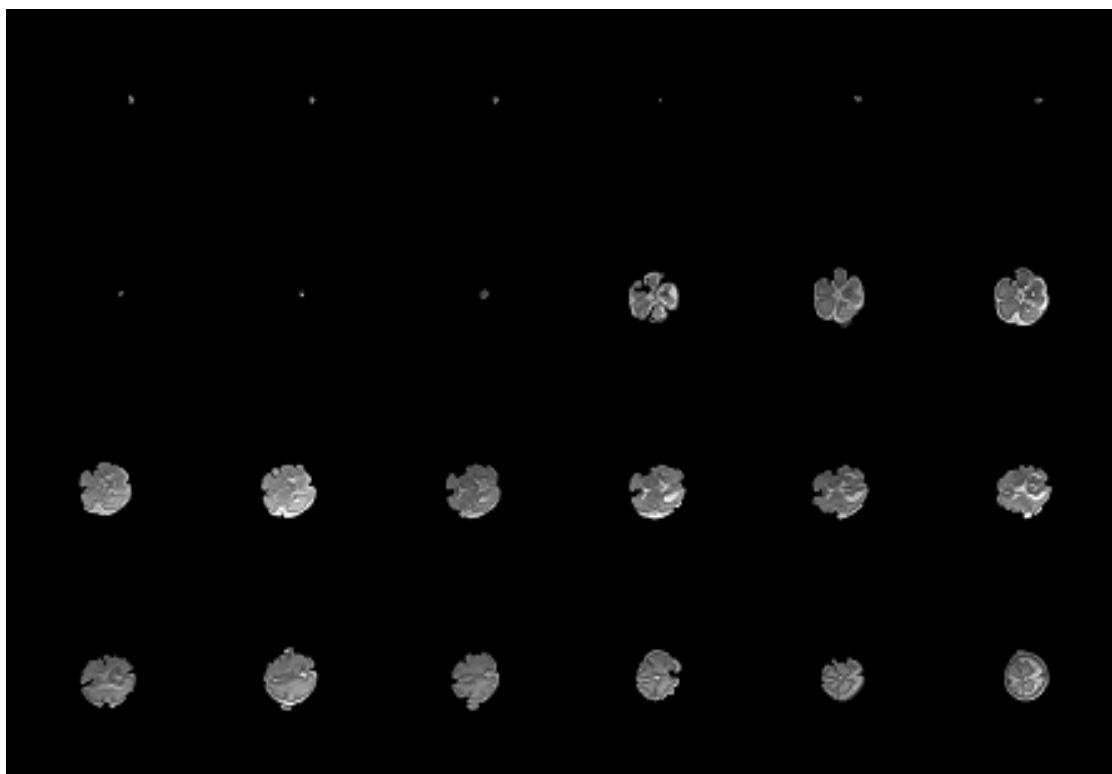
Sample of extracted fetal brain MRI slice
